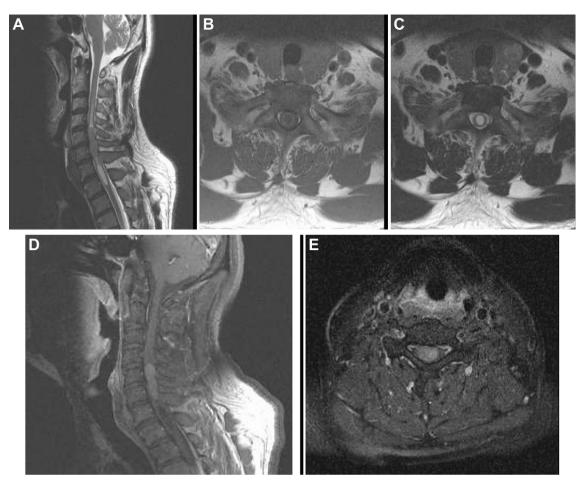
(A) Sagittal T2-weighted images show a mass lesion at the C5—C6 level with spinal cord edema. (B) Axial T1- and (C) T2-weighted images show a well-defined long lobulated cystic structure in the central region of C7—T1, suggesting a polar cyst. (D) Sagittal and (E) axial contrast-enhanced T1-weighted images show a sharply delineated ovoid enhancing mass within the cervical spinal cord at the intramedullary level of C5—C6, measuring approximately 3.6 cm in the greatest dimension.
